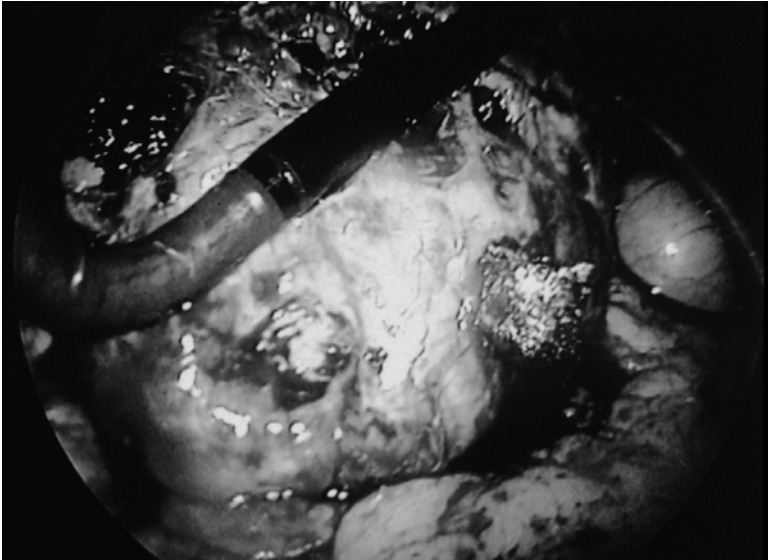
The laparoscopic ultrasound facilitates detection of cysts and is particularly useful in ADPKD and for intraparenchymal cysts.
